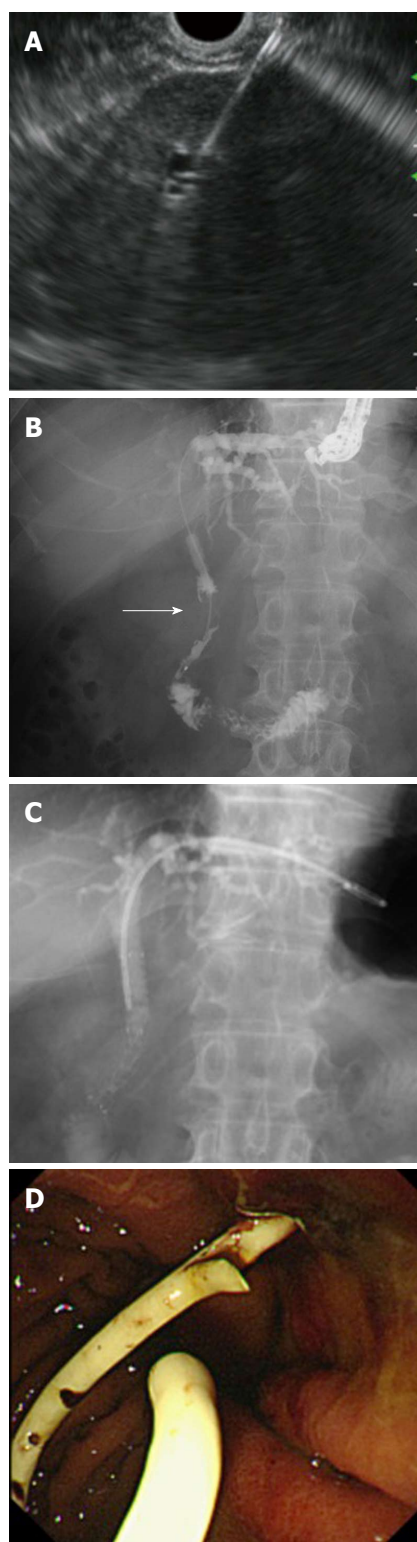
Endoscopic ultrasonography-guided hepaticogastrostomy. A: Left intrahepatic bile duct was punctured; B: Cholangiography showing distal malignant stricture (arrow); C: Following antegrade self-expandable metallic stent placement, a plastic stent was deployed between the intrahepatic bile duct and stomach; D: Endoscopic view showing that the distal end of the plastic stent was located at the stomach.
